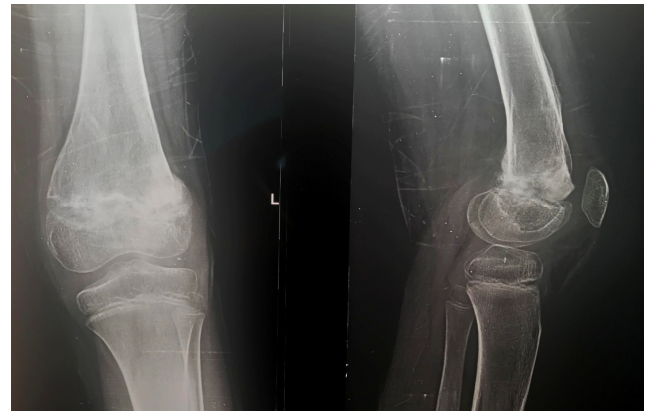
4-month Post-Op radiographs
